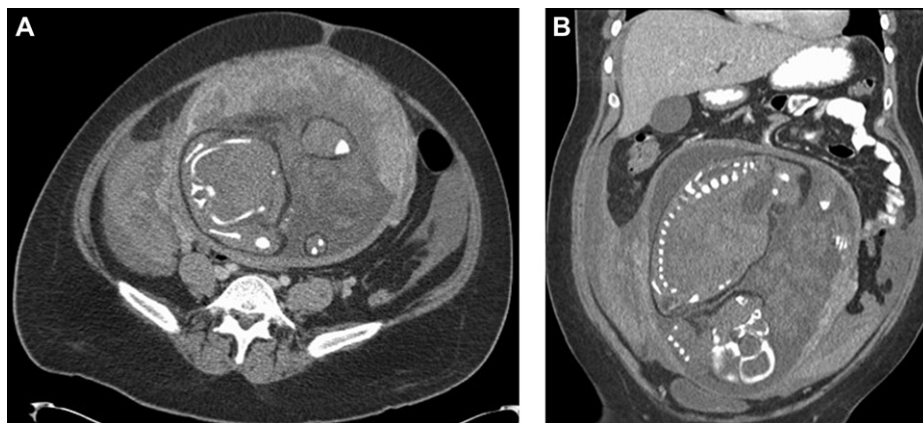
Uterine rupture in a 34-year-old patient with acute right lower quadrant pain after a failed attempt at a vaginal birth, after previous caesarean section. (A) Axial and (B) coronal contrast-enhanced computed tomography, demonstrating a relatively large amount of hemoperitoneum, particularly in the right pelvis, which proved to be related to uterine rupture at subsequent emergency caesarean section.
